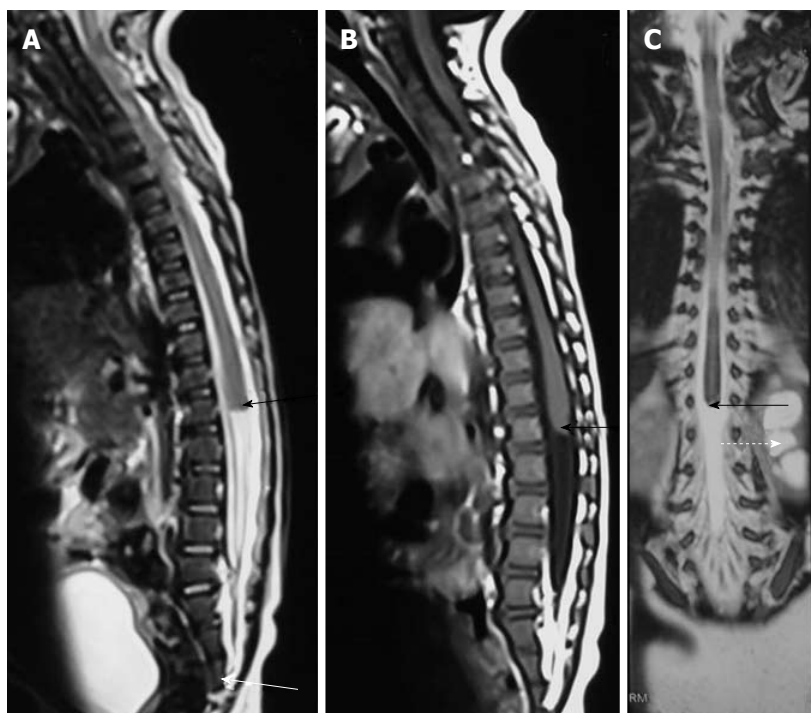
Caudal agenesis. T2 weighted sagittal (A), T1 weighted sagittal (B) and T2 weighted coronal (C) MR images showing type II caudal agenesis. There is non-development of distal sacral vertebra (white arrow in A) with abnormal termination of conus medullaris (black arrow). The child also has associated left hydronephrosis (dashed arrow in C).
